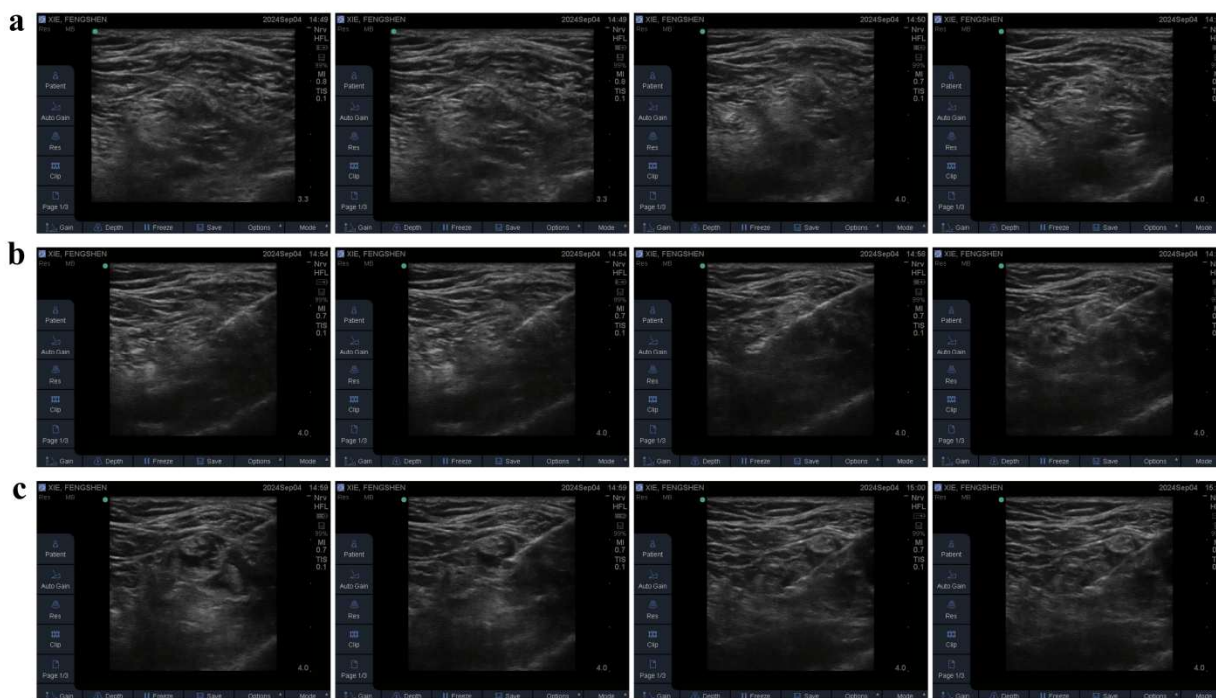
Ultrasound monitoring image during puncture. (a) before puncture, (b) during puncture, and (c) after puncture.
